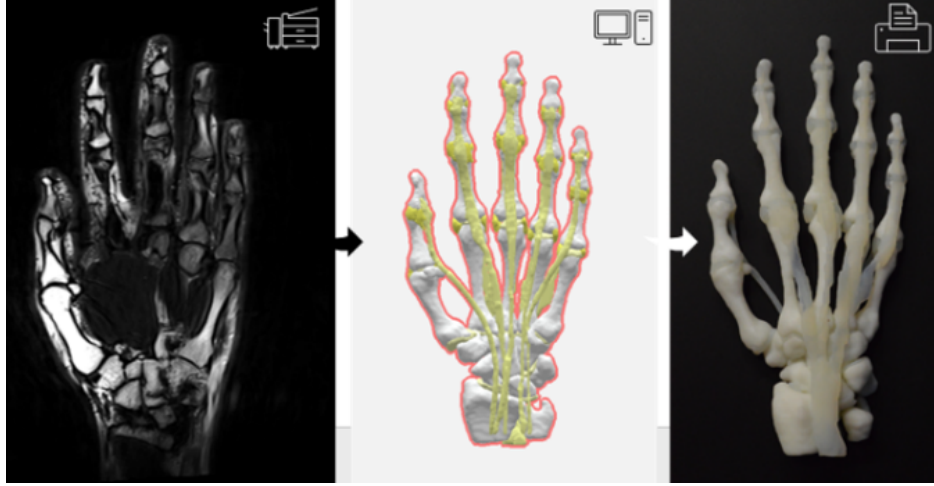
Methodology for developing anthropomorphic structures for the creation of an instrumented anthropomorphic hand beginning with magnetic resonance imaging (MRI) of hand to digital 3D representation of the bone, tendon and ligament structures in the hand and lastly, an anatomical 3D-printed model of the hand.
